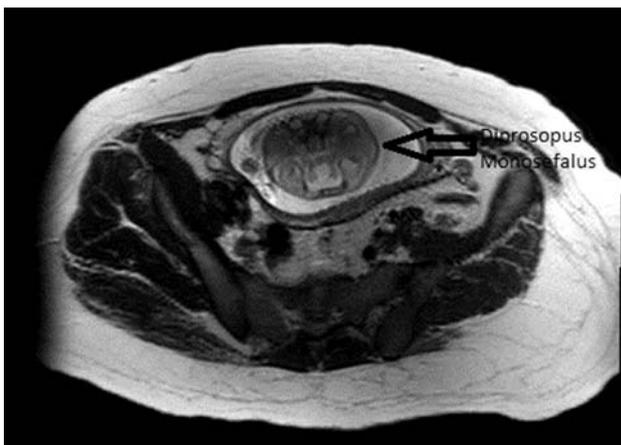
MRI view of double-face, single head.
